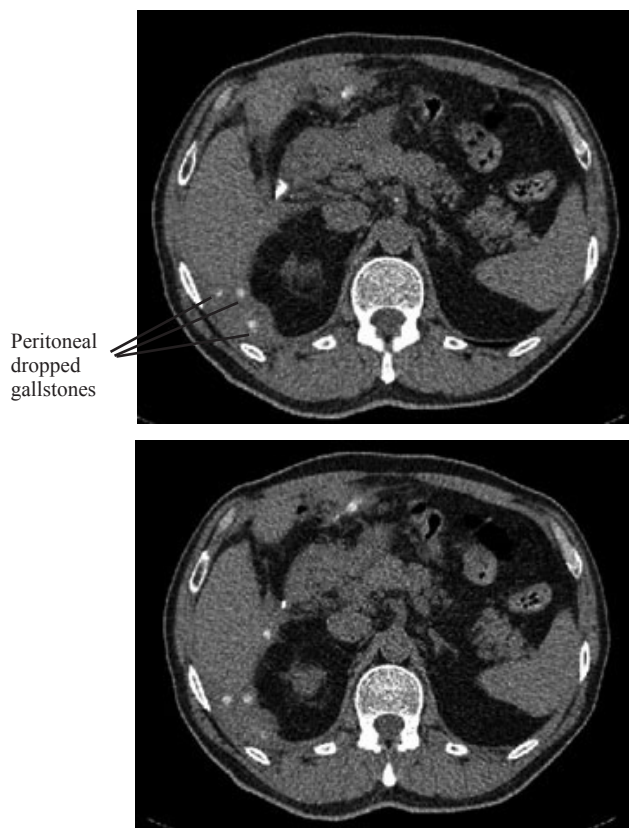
Post laparoscopic abdominal CT scan of the patient. Some stones were seen in the peritoneum near the liver.
